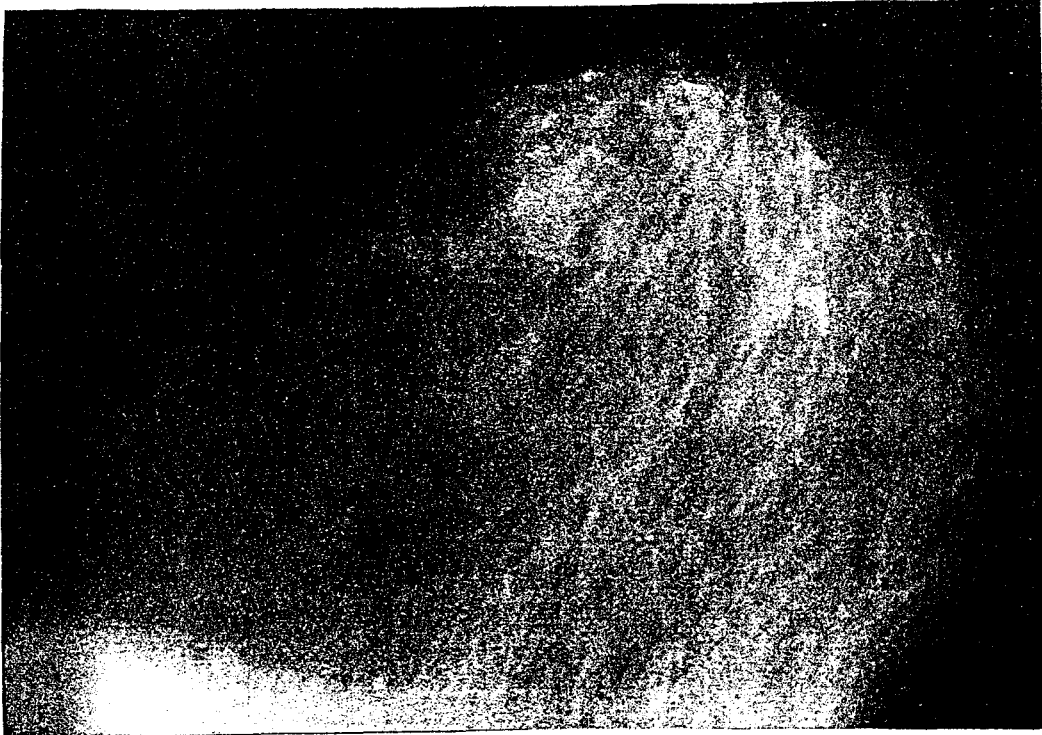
(a) Left side breast, x-ray image.
